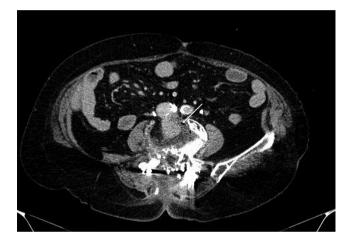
Contrast CT in the axial view showing a dilatation of the inferior vena cava (IVC) in the intradiscal space of L4–L5 (arrow, venous phase).
